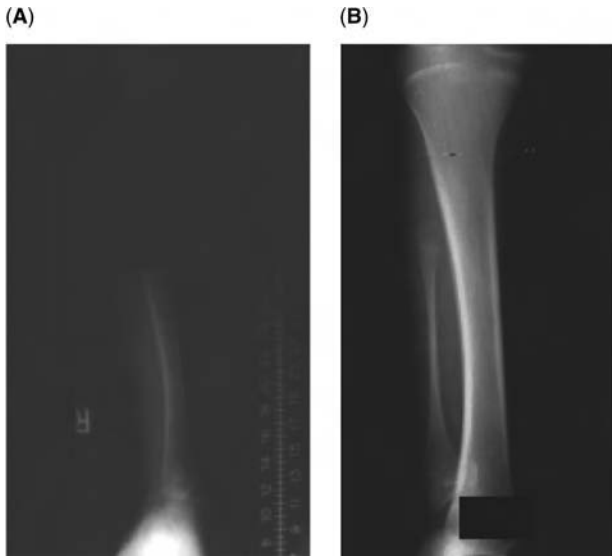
(A) Toddler X-ray with no visible fibula. (B) Subsequent X-ray with miniature fibula.
